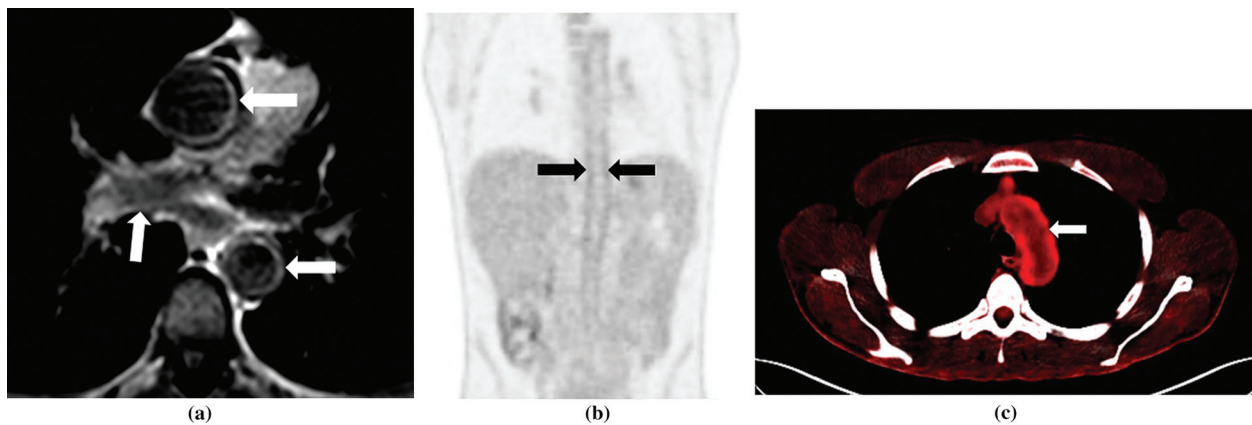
a-c. Thoracic MRI and PET/CT scan images. Arterial wall thickening with intravenous contrast uptake increase was observed on MRI in the ascending aorta, descending aorta, and right pulmonary artery (arrows in a). Increased radiopharmaceutical uptake on PET was observed in descending aorta (arrows in b, coronal image) and in the aortic arch (arrow in c, axial image).
